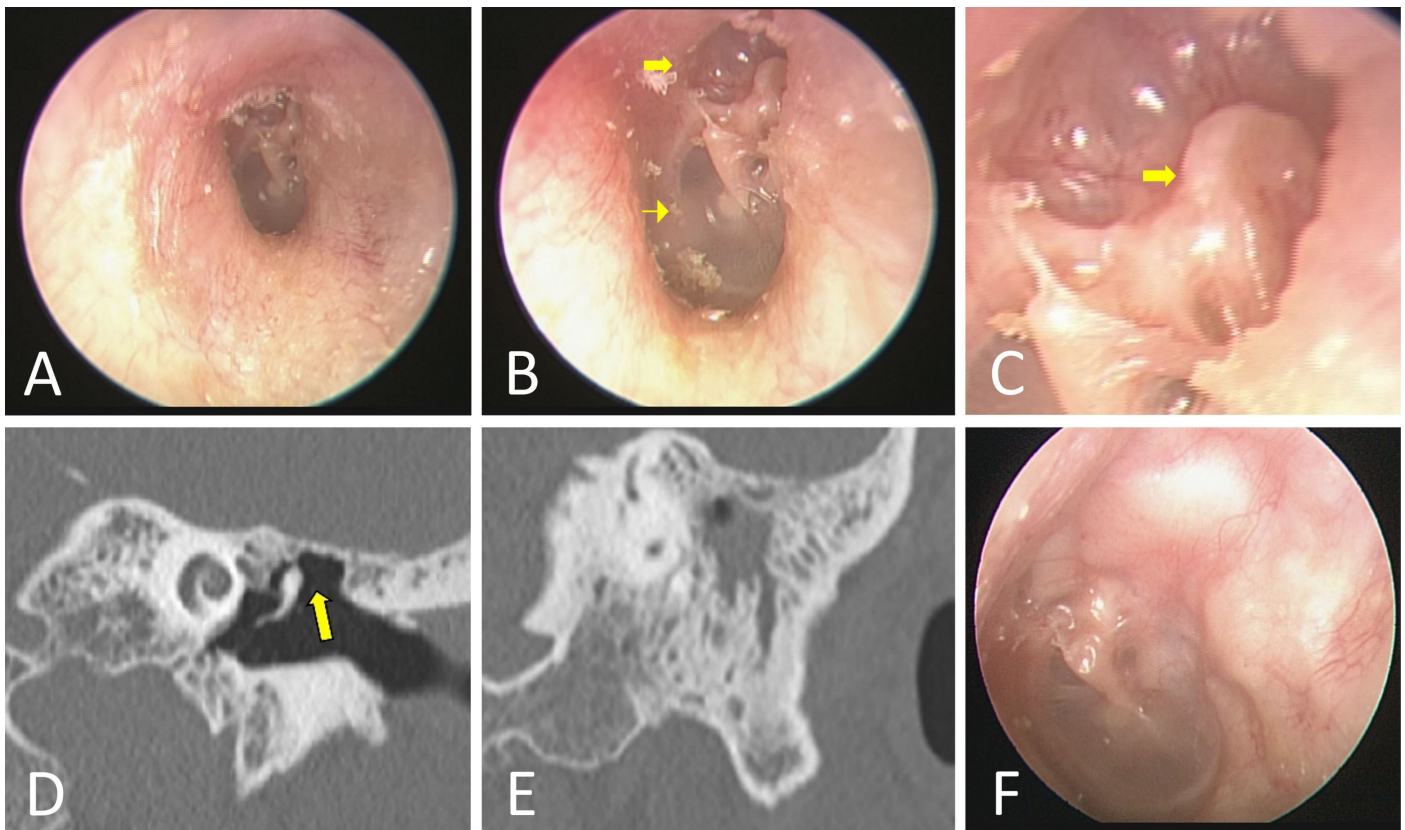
The otoscopic examination of the left ear reveals a deep retraction pocket in the par flaccida (A), as well as severe erosion of the scutum (arrow in panel B). While the pars tensa is normal (arrowhead in panel B), the malleus head is exposed and wrapped by the par flaccida (arrow in panel C). A clean and clear bottom is evident in the retraction pocket, and there are no signs of infection or accumulation of debris (C). High-resolution computed tomography (HRCT) images of the left temporal bone reveal scutum erosion (arrow in panel D) and a soft tissue mass in the mastoid (E). In five years of follow-up, there has been no evidence of recurrence of the disease (F).
